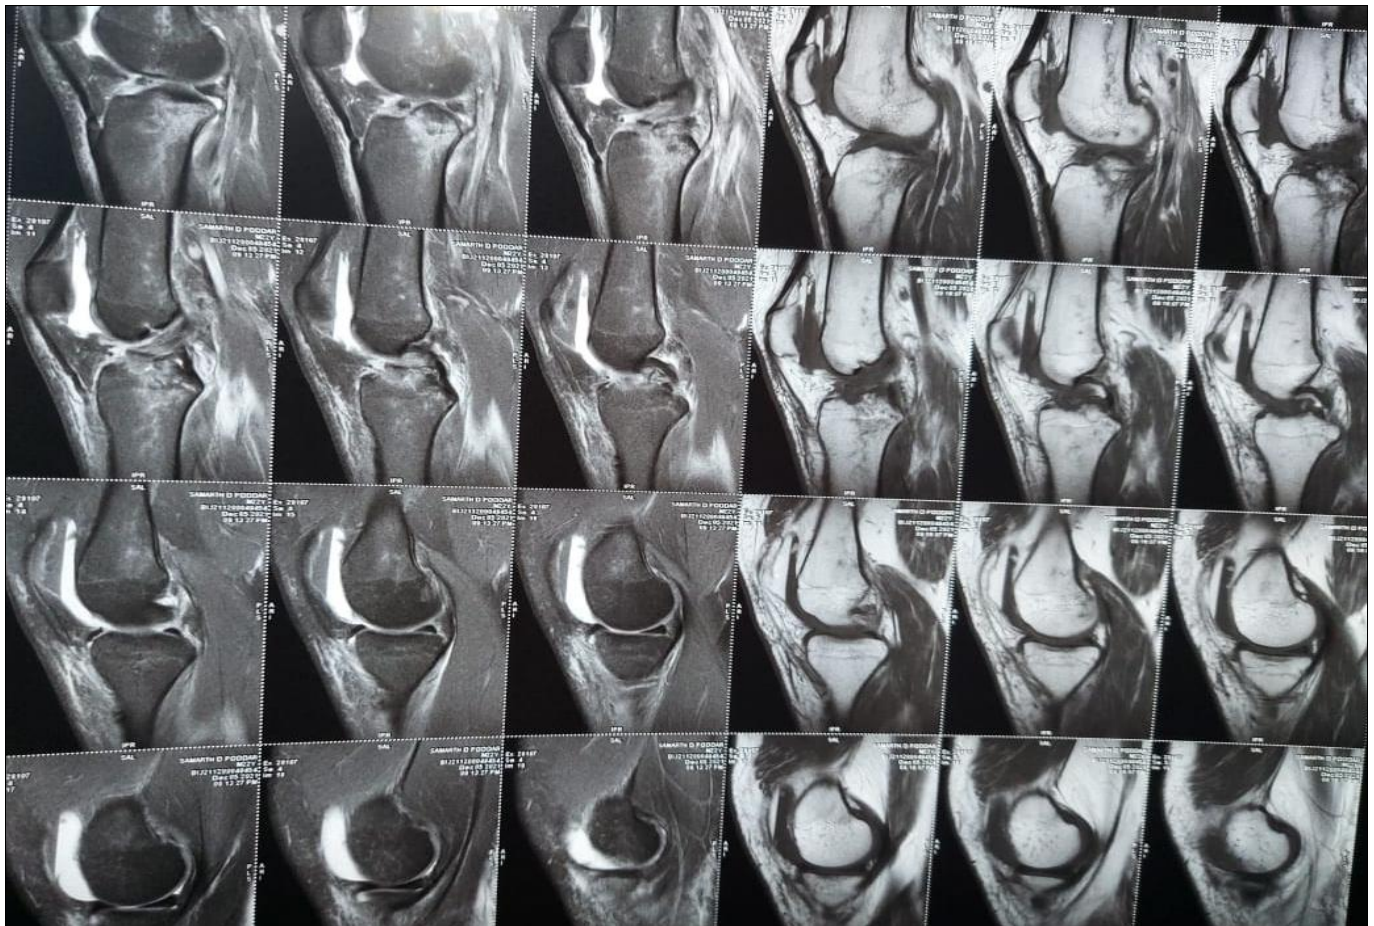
Sagittal MRI image showing an avulsed bony fragment of the tibial eminence from the anterior cruciate ligament attachment base.
